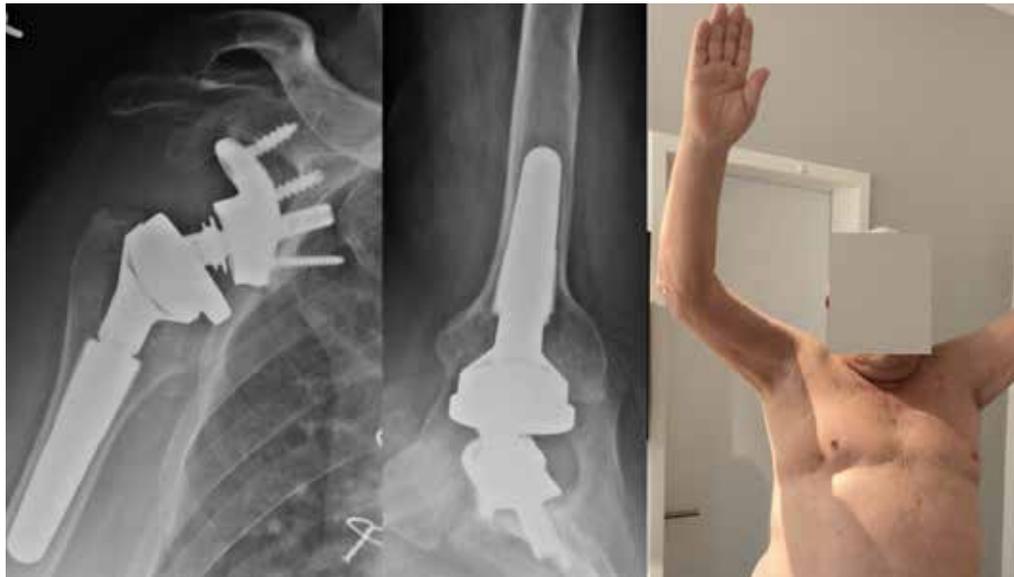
Postoperative X-Ray and clinical result at 4 weeks. It is of course possible to achieve a similar good outcome using a big structural graft. However, a "standard" reconstruction with a bone graft and a "normal" baseplate may insufficiently lateralise the centre of rotation or even compromise the clinical result (graft resorption, baseplate anchorage problems, etc.). Bone grafting is intraoperatively much more complex and challenging to the surgeon than using the precisely predefined custom-made implant.
